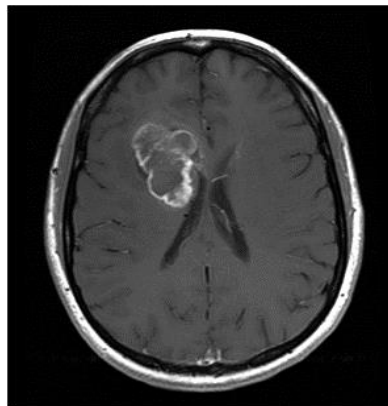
Case study of an MRI
